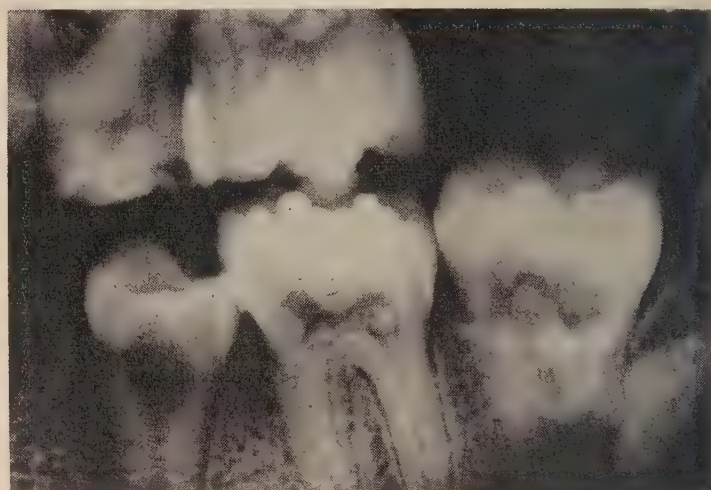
Radiographs of an 11 year old girl depict large flame-shaped pulps containing numerous areas of calcification.
